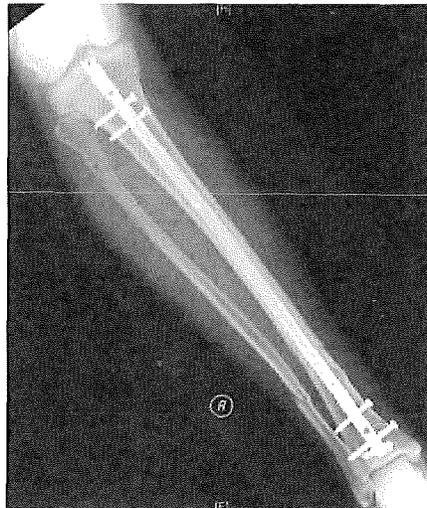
Radiograph of Right Tibia Fracture with IMN fixation<sup>18</sup>
